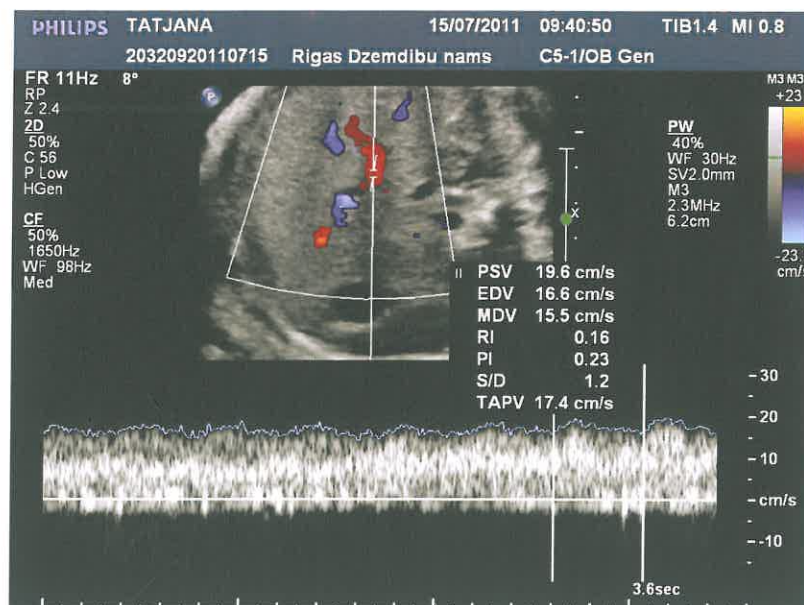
Figure N 13. Colour Doppler image of *ductus venosus* trace (gestational age 30 weeks)
